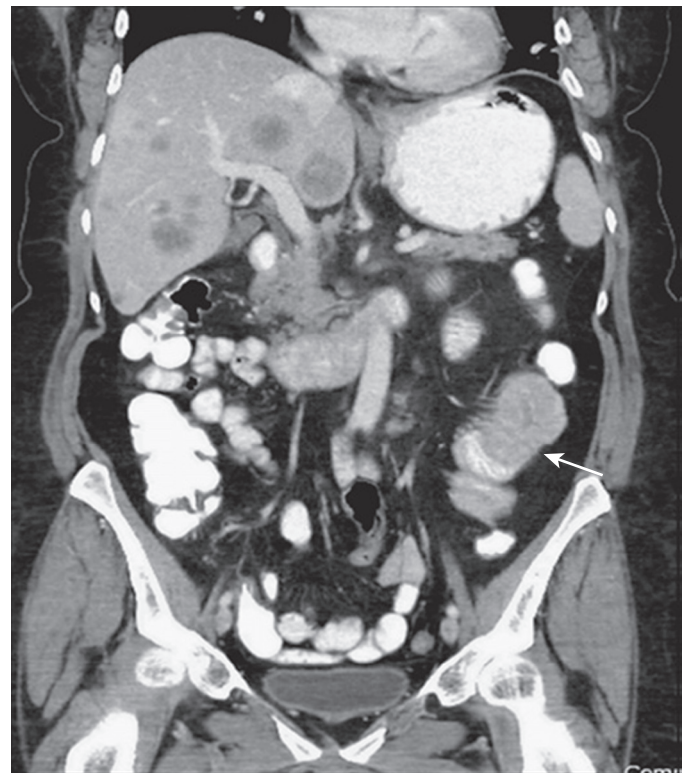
Late diagnosis of SB malignancies. Shown is a CT scan of the abdomen and pelvis with IV contrast in a patient with chronic recurrent nausea and vomiting. Coronal images show a mass in the proximal jejunum (arrow) consistent with proximal SB malignancy; also note liver metastases. Surgical pathologic findings showed adenocarcinoma.
